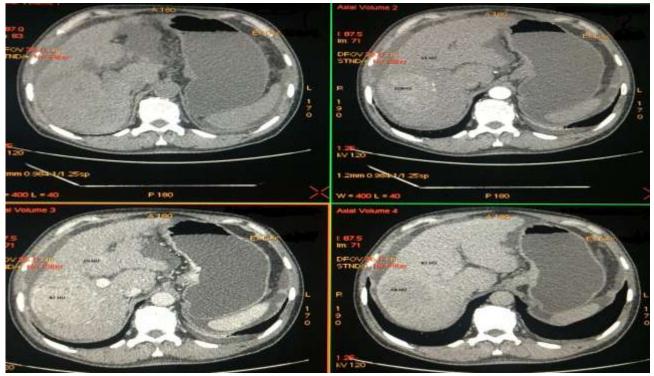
HCC on Triphasic CT scan showing enhancement on arterial phase and washout on portovenous phase. Lesion has become hypodense on delayed phase Quantitative washout=100 x liver attenuation on delayed phase/lesion attenuation on delayed phase =100 x 87/68 = 127.
